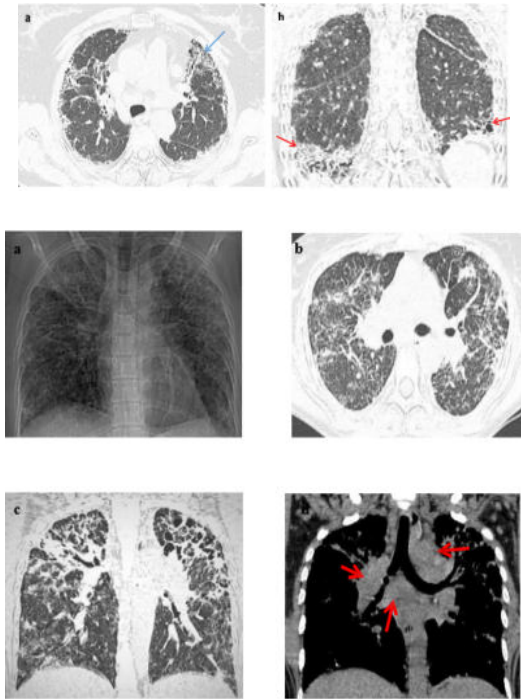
45-year-old female presented with a complaint of dyspnoea and weight loss for one year. The patient had raised ACE levels and is a biopsy-proven case of sarcoidosis. a) X-ray chest PA view shows extensive reticular and nodular opacities involving the bilateral lung fields diffusely. B and c) Limited axial and coronal sections of HRCT Chest shows the presence of multiple nodules along the fissure and peri-bronchovascular interstitium with the presence of interlobular septal thickening. Multiple subpleural fibrous bands with adjacent tractional bronchiectasis are also seen. These findings diffusely involve the bilateral lung fields (upper lobe > lower lobe). d) Coronal reconstruction image of the mediastinal window shows multiple enlarged para-tracheal, pre carinal, subcarinal and bilateral hilar lymph nodes (marked with red arrows).
